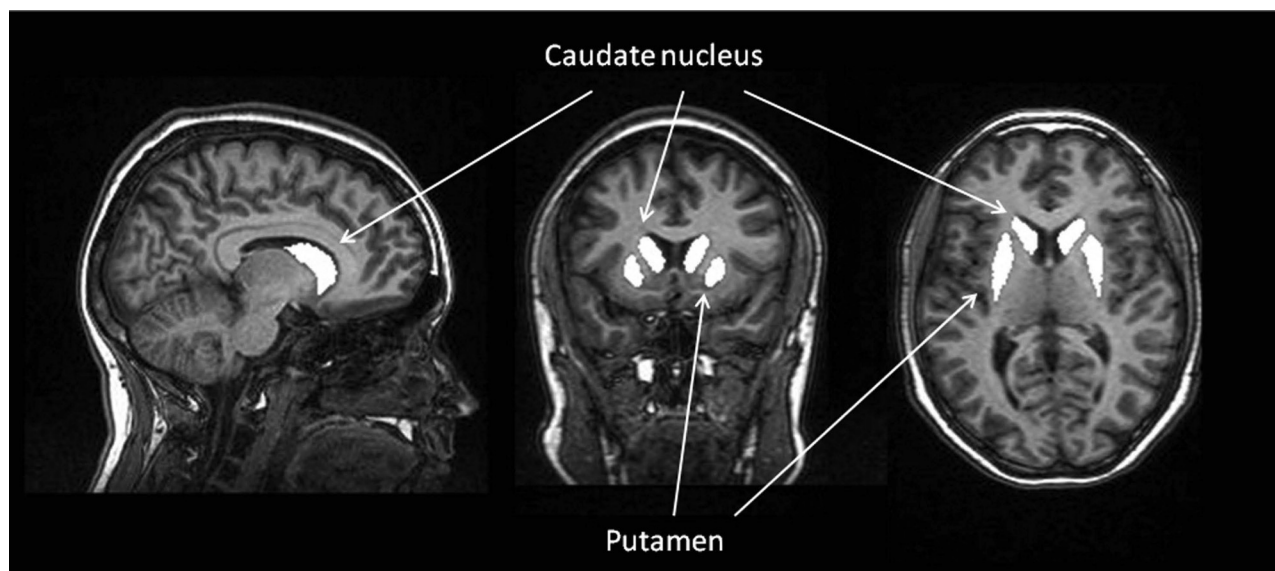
The caudate nucleus and putamen extracted from the T1-weighted MR images (sagittal, coronal, and axial views).
